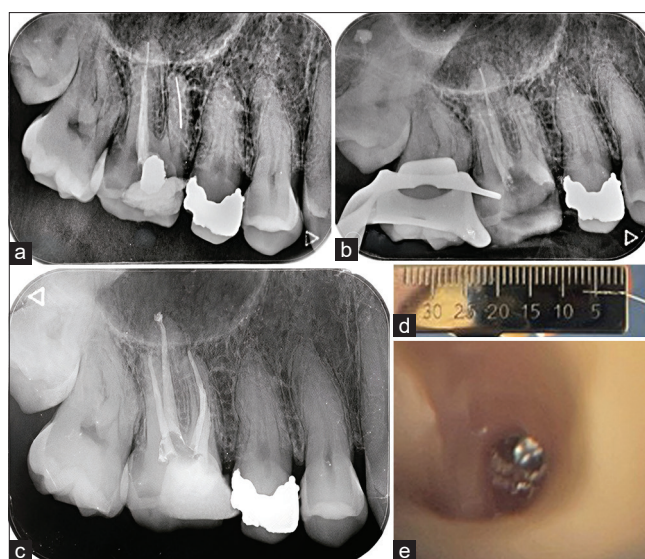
Case 3 with a separated instrument in tooth #3. a) Radiographic examination showing three broken instruments in the MB canal. b) The instrument was retrieved from the canal and confirmed with a radiograph. c) Root canal treatment completed. d) The length of the separated instrument. e) Coronal portion of the separated instrument in the mesiobuccal canal was visualized under a DOM.
